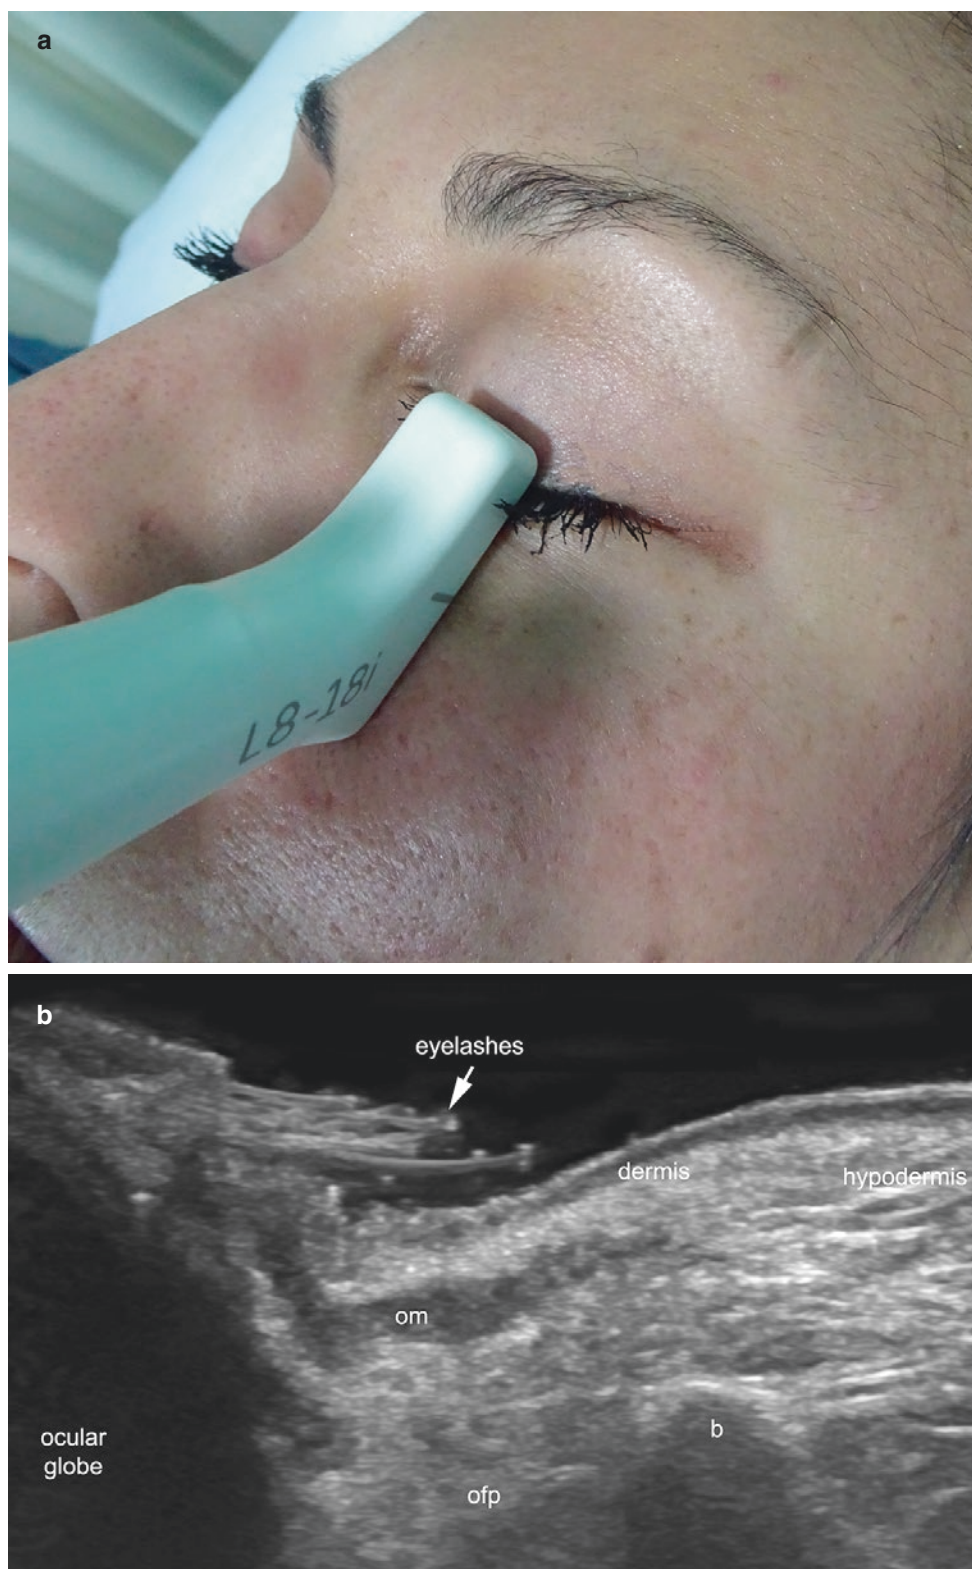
Orbicularis muscle lower part (orbital and palpebral). (a) Clinical image shows the location of the probe. (b) Ultrasound (longitudinal axis) demonstrates the hypoechoic thin band of the palpebral
